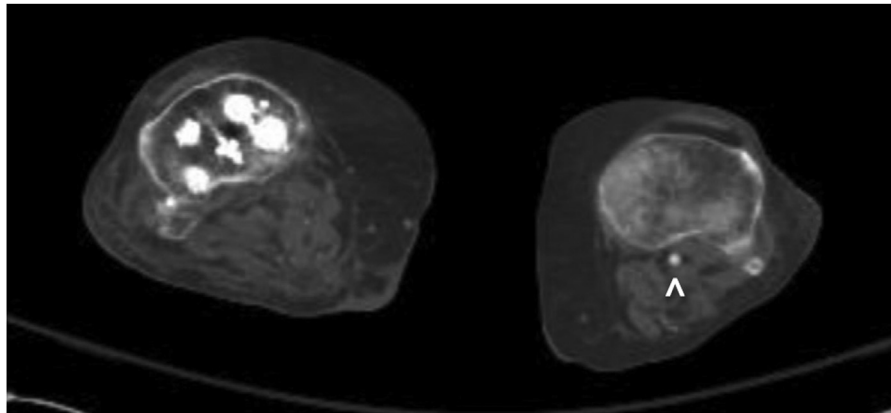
CT angiogram of bilateral lower extremities at the level of the tibial plateau, demonstrating a lack of filling in the right popliteal artery. The left popliteal artery enhances with contrast (white arrow head).
